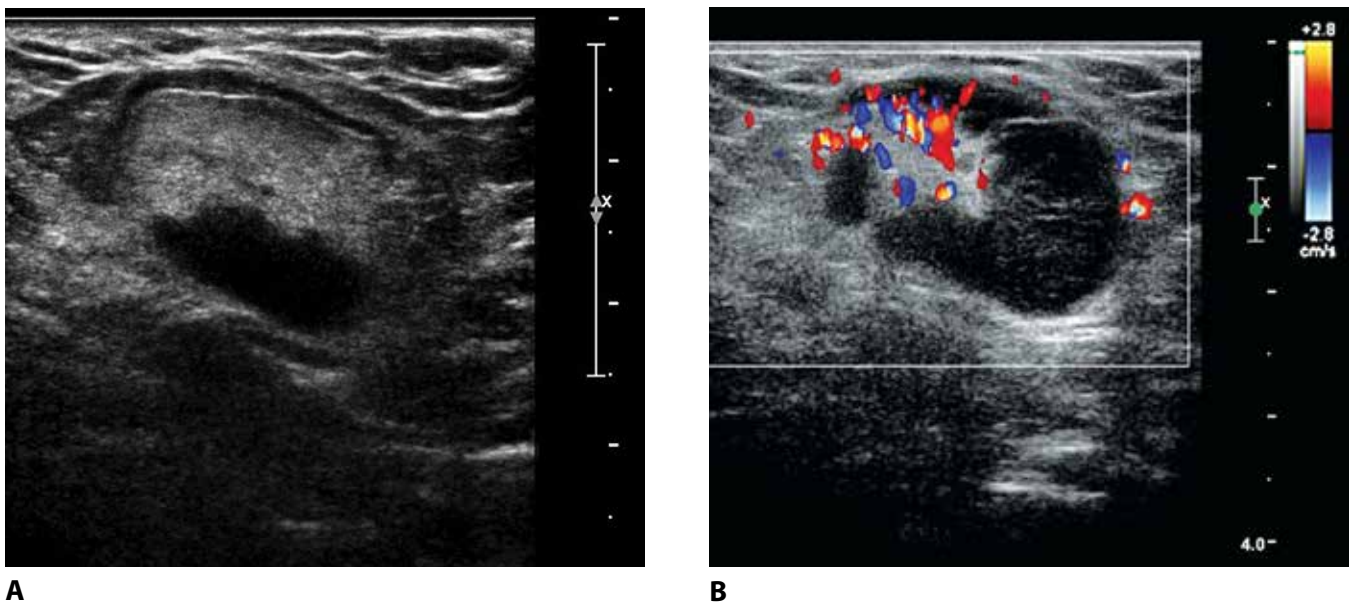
LYMPH NODES — AXILLARY. Metastatic involvement of this LYMPH NODE (a) B-mode; (b) color Doppler, showing eccentric focal cortical thickening with a large area of hilar fat compressed by the cortical metastasis. The focal metastasis shows decreased echogenicity, and vascularity is absent (b).
